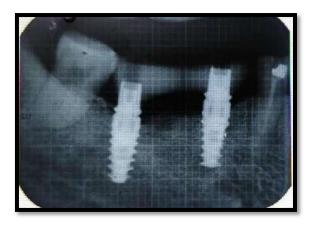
IOPA radiograph with grid at the time of prosthesis placement
